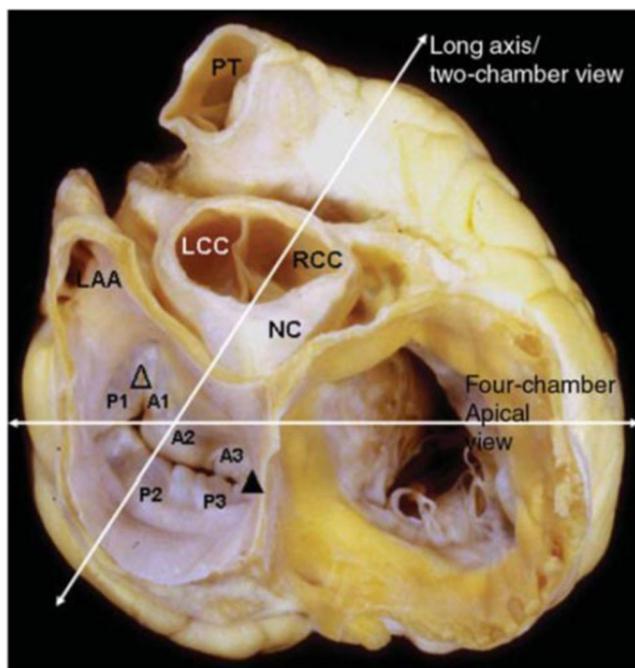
Mitral valve anatomy from the perspective of the left atrium. The anterolateral commissure (Δ) is adjacent to the left atrial appendage (LAA), and the line of coaptation extends in a curved line towards the interatrial septum ending at the posteromedial commissure (Δ). The anterior leaflet (A1–A3) abuts the aortic valve while the posterior leaflet (P1–3) attaches to the posterior myocardium. Using the Carpentier system, the most lateral is termed “1” and most medial segments of each leaflet is “3”. (Figure adapted from McCarthy, K.P. et al. *Eur J of Echocardiography* 2010;11:i3-i9) [9]
